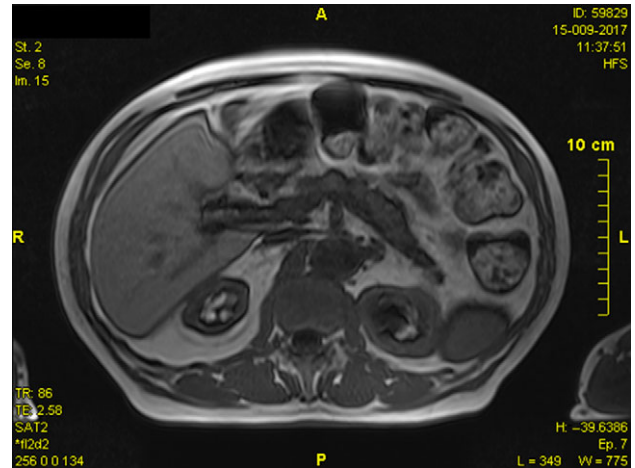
MRI after 1 month of treatment with steroids showing normal in size pancreatic parenchyma without signs of inflammation
